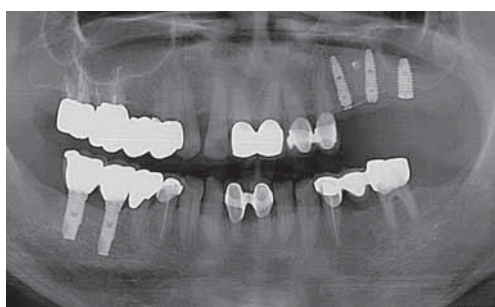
Postoperative radiographic view.
